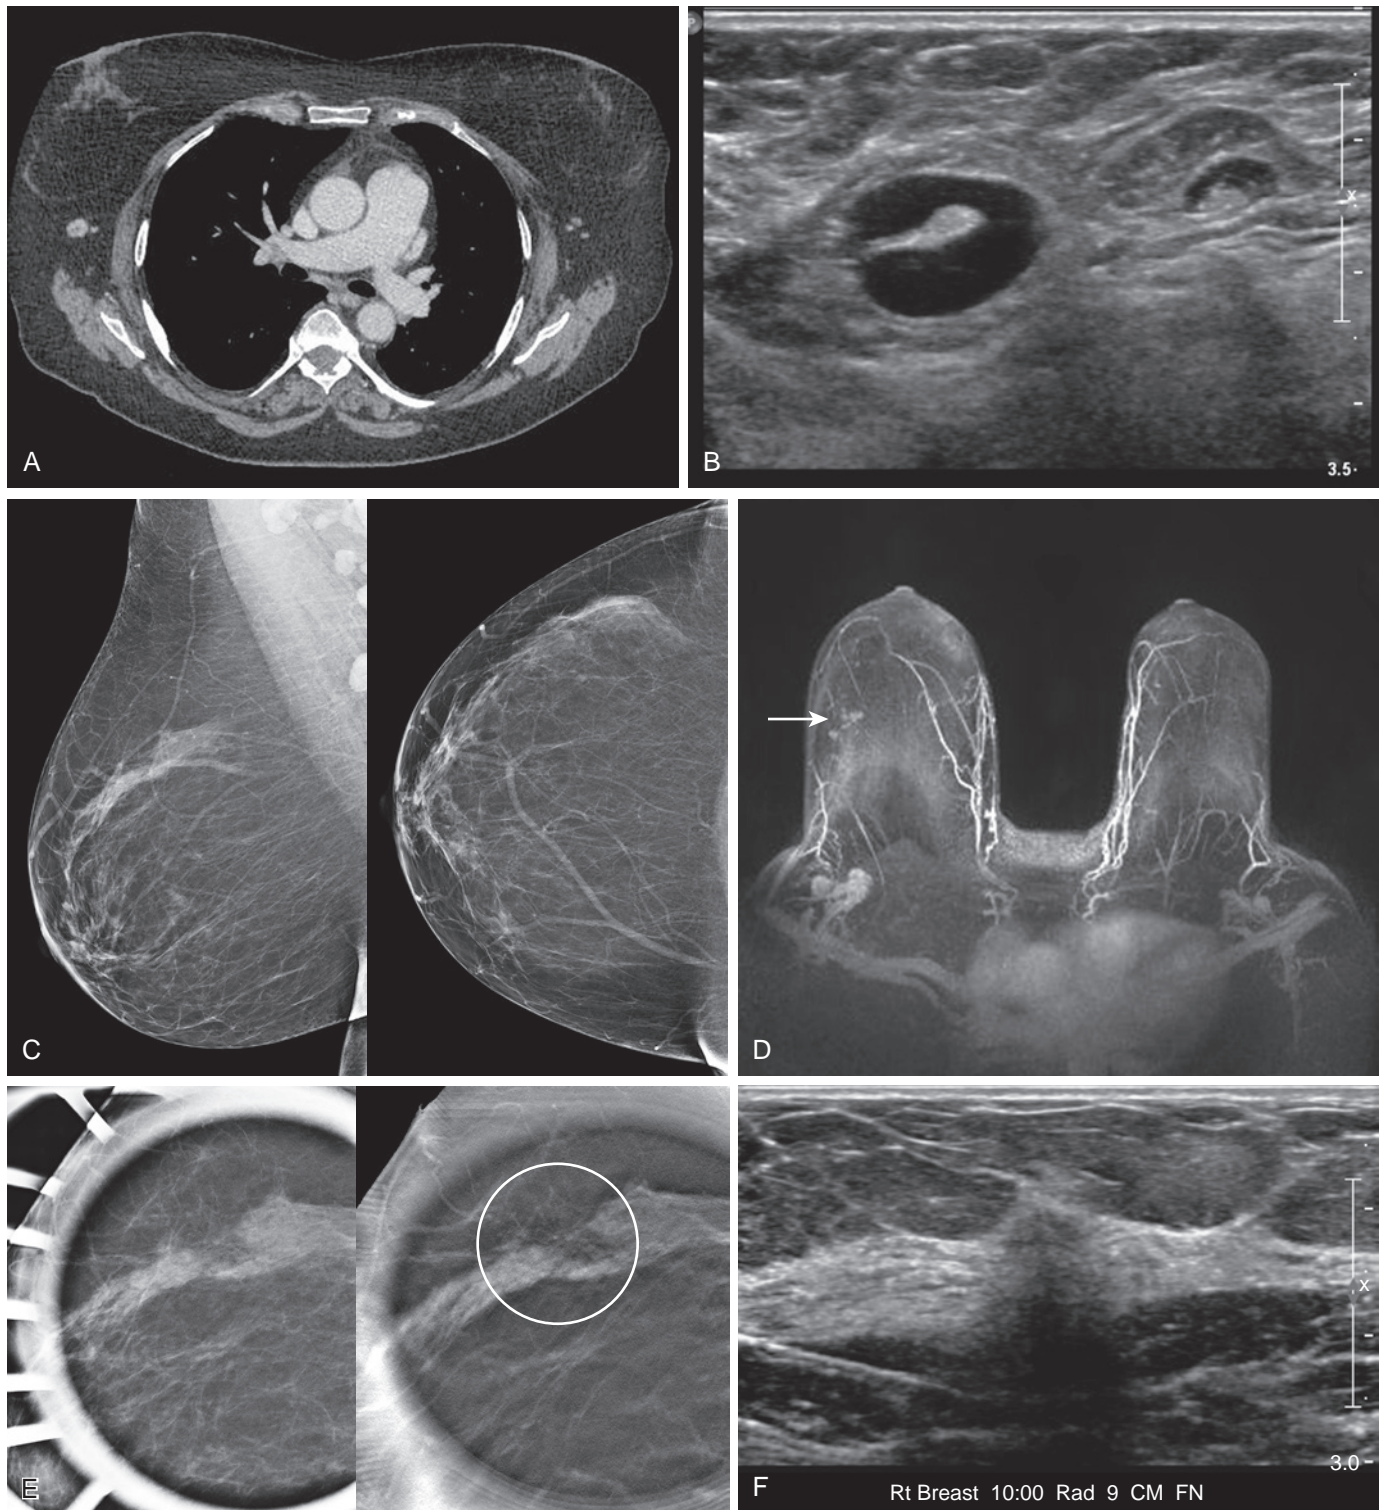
(A) A 57-year-old woman, 5-year status posttreatment for melanoma, underwent her last staging computed tomography scan, in which slightly prominent nodes were noted in the right axilla. (B) Right axillary ultrasound demonstrates the prominent nodes and biopsy revealed adenocarcinoma, consistent with breast primary. (C) Initial right diagnostic mammogram shows nondense tissue and no abnormality. (D) Maximum intensity projection image from contrast-enhanced magnetic resonance imaging showed both the enlarged axillary nodes and a small enhancing mass in the lateral breast (*arrow*). (E) Two-dimensional and tomosynthesis spot views demonstrate architectural distortion in a predominantly fatty area of tissue (*circle*). (F) Targeted ultrasound reveals a corresponding ill-defined hypoechoic area with distortion of the tissue.
